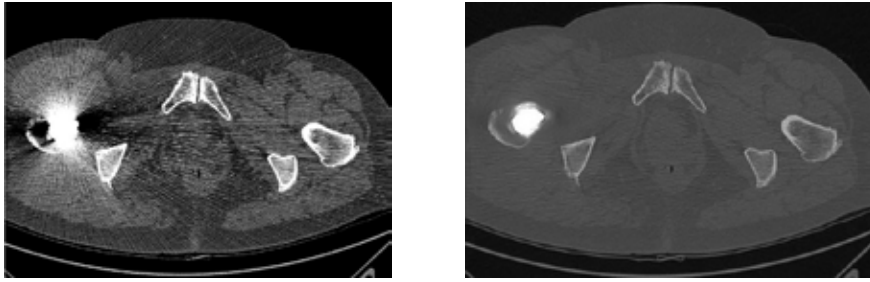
an example of an original CT slice including the prosthesis (on the left side) and the corrected imaged once suppressed the metal artefact (on the right side).
